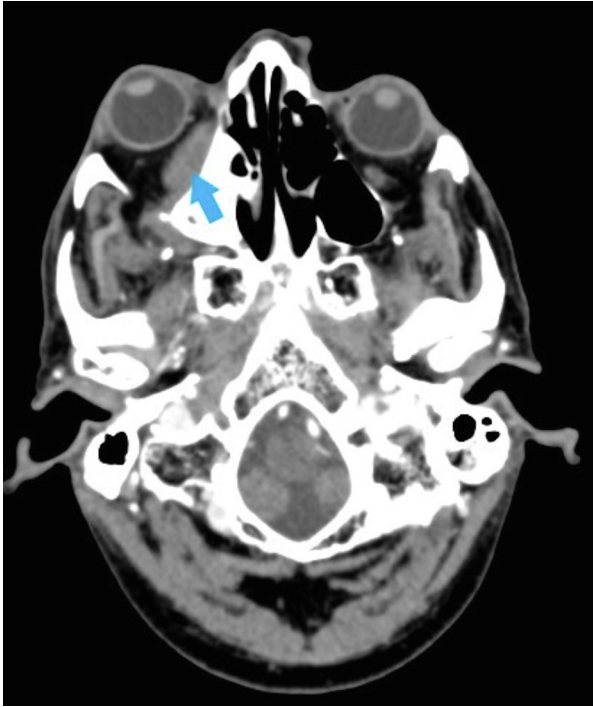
A contrast enhanced axial CT scan image showing right proptosis due to a homogeneous soft tissue mass (arrow), extending along the medial wall of the orbit, occupying the extraconal and intraconal compartments.
